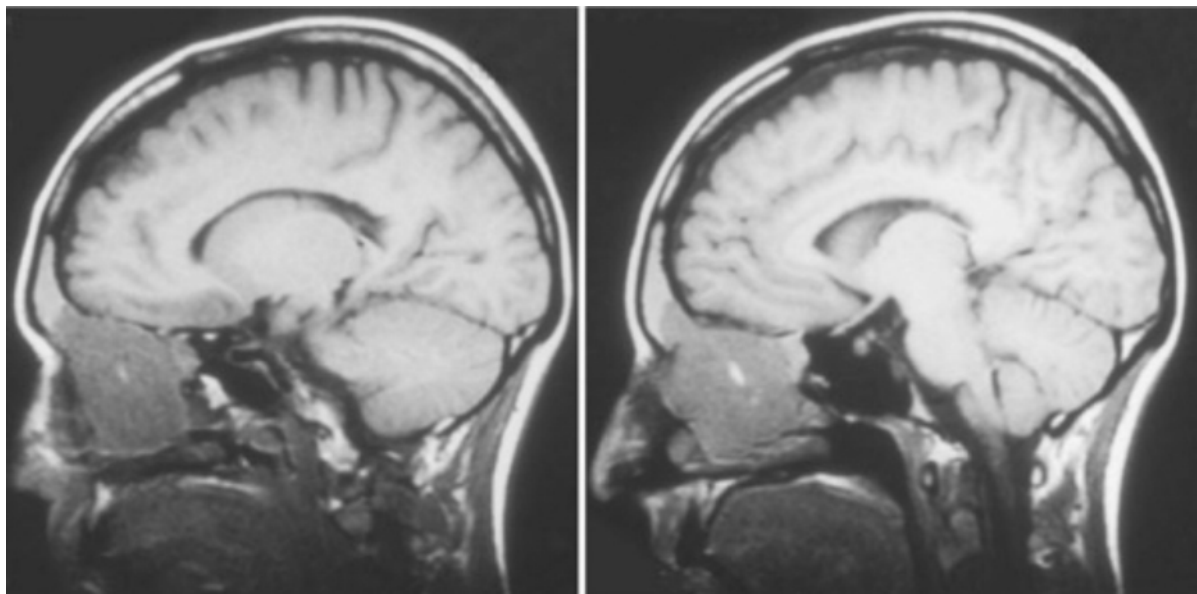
This patient has an extensive neoplasm involving the nasal cavity and paranasal sinuses. Magnetic resonance imaging demonstrates protrusion of tumor into the inferior portion of the frontal sinus. There is evidence of tumor extension through the bone of the anterior cranial base with possible involvement of the dura.
